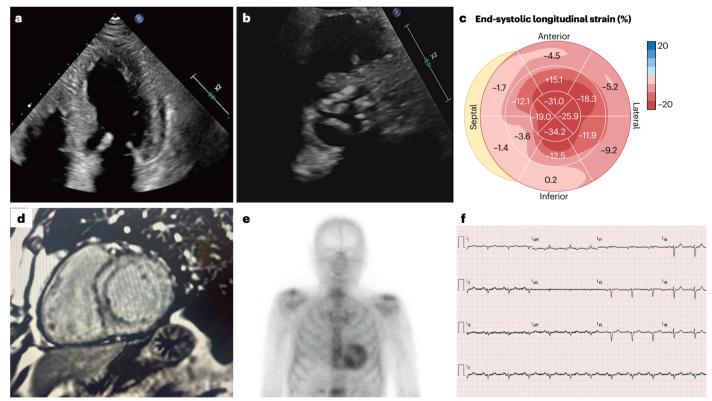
Cardiac amyloidosis and aortic stenosis. a-c, Transthoracic echocardiography of a patient with concomitant transthyretin cardiac amyloidosis and aortic stenosis. a, Four-chamber view showing concentric left ventricular hypertrophy. b, Parasternal short-axis view showing calcification and severe narrowing of the aortic valve. c, Echocardiographic longitudinal strain bull's-eye plot showing reduced values of strain with characteristic sparing of the apical segments ('apical sparing' pattern, with red colour indicating preserved
